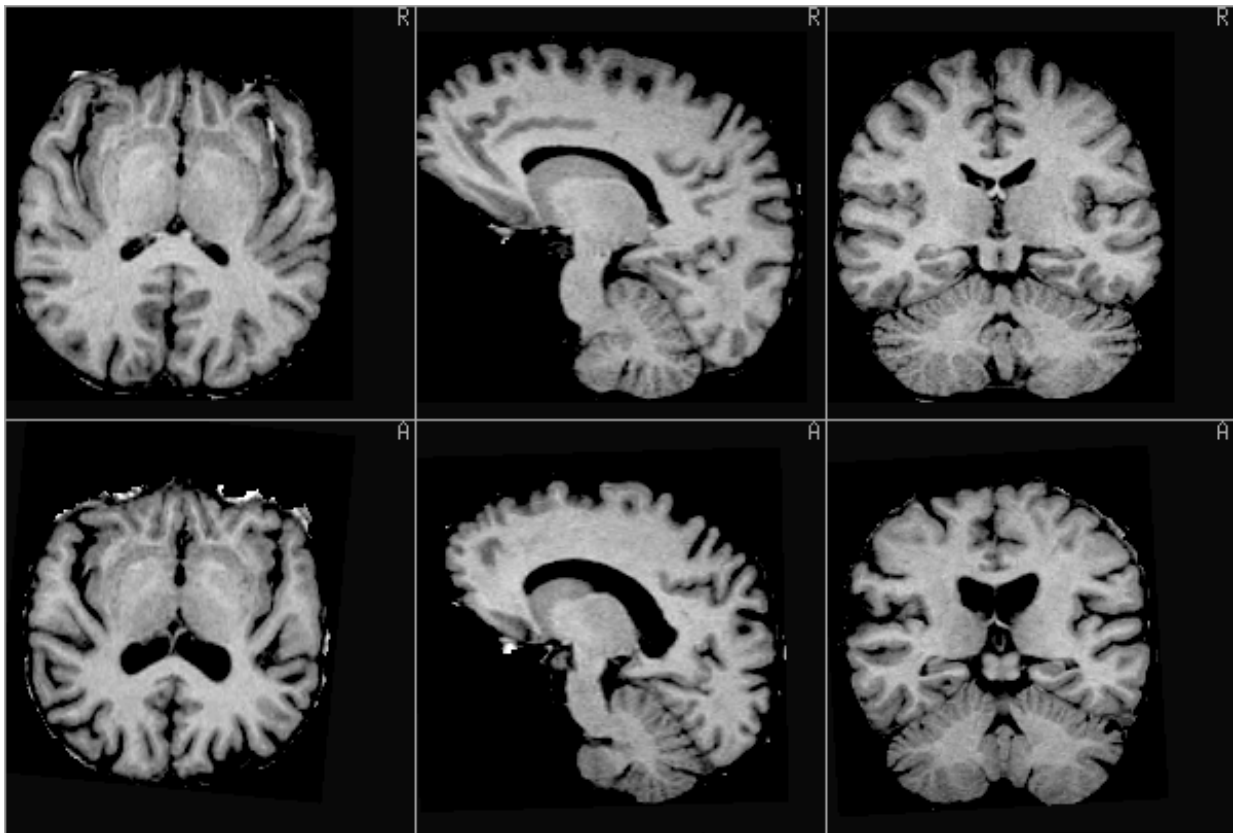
Orthogonal slices through the MRI data sets used as a target reference spaces: Top row shows the 33Y/old male used as a younger reference anatomy. The bottom row shows the 72 Y/old female used as the older reference anatomy. Note differences in the size of the ventricles and the sulcal C.S.F. spaces.
